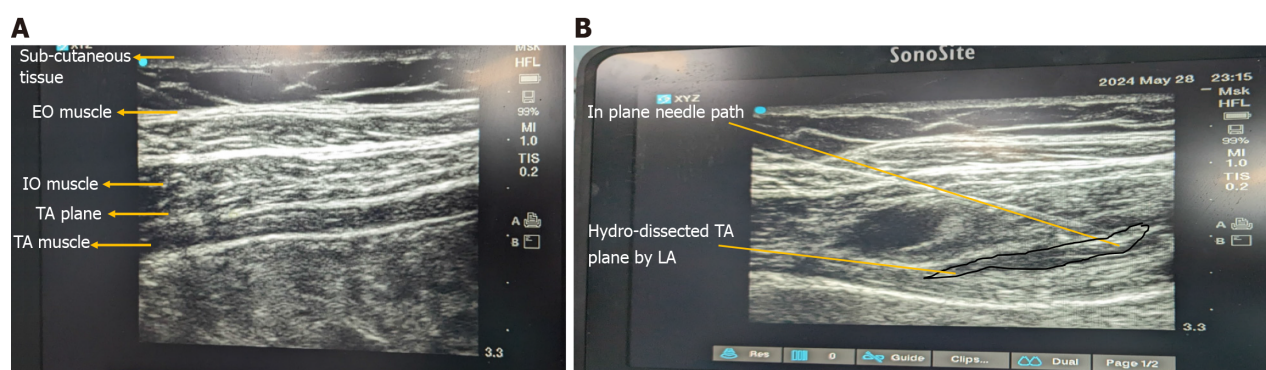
Transversus abdominis plane block can be performed blindly but ultrasonogram guidance increases precision. A: Ultrasonogram (USG) anatomy of abdominis plane block (TAP) block (arrows); B: USG-guided TAP block view (arrows). EO: External oblique; IO: Internal oblique; LA: Local anaesthetic; TA: Transversus abdominis.
